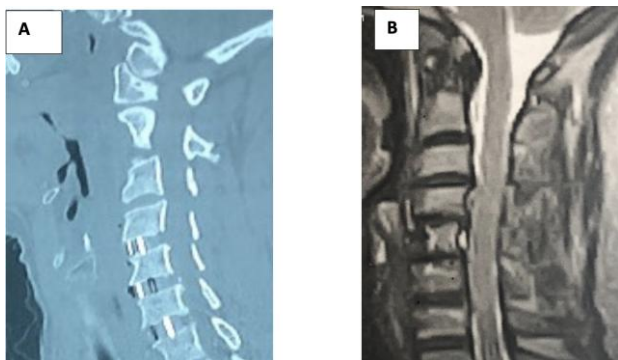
A) Postoperative C.T scan of the cervical spine of a patient complaining of axial pain after doing ACDF with the insertion of C4-5, C5-6, and C6-7 cages; B) MRI cervical spine of the same patient showing adjacent segment failure at the level of C3-4
